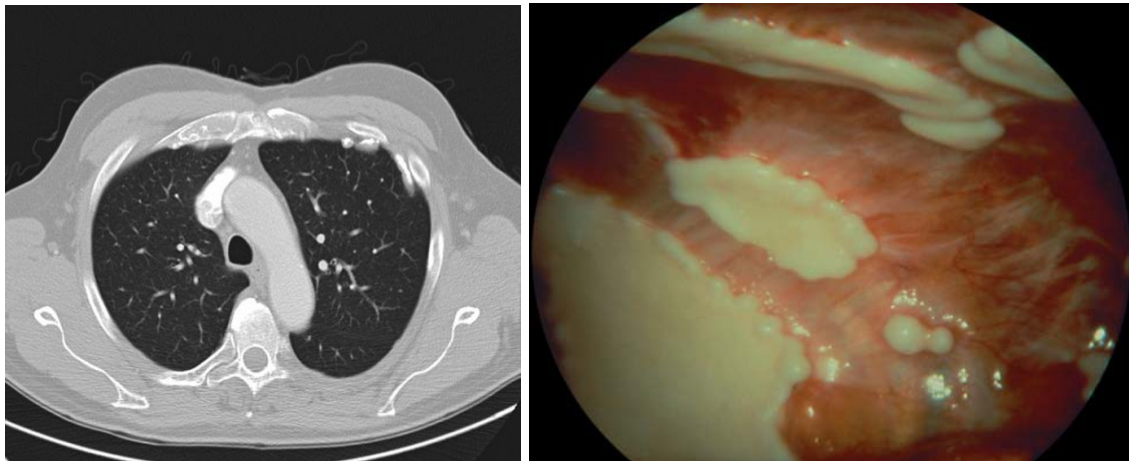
(A) Radiological and computed tomography scan of the thorax demonstrating asbestos-related pleural plaques. (B) Thoracoscopic view of PP on the parietal pleura. Pleural biopsies have done at the level of non-specific inflammation to rule out an early-stage malignant mesothelioma.
